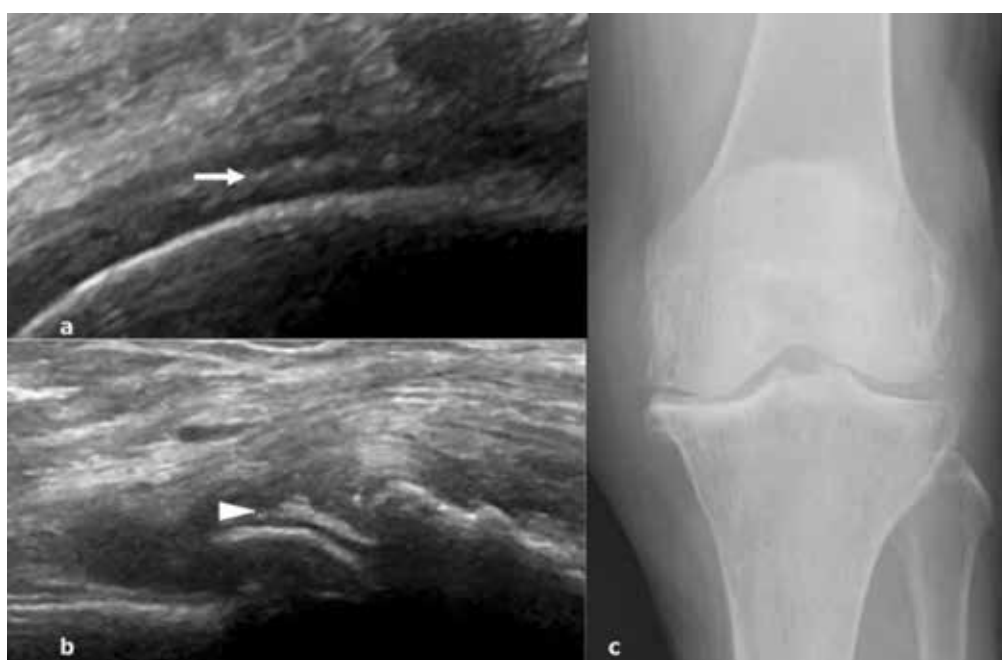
a Calcification in medial meniscus in patient with calcium pyrophosphate deposition disease (*arrow*). b Calcification in femoral hyaline cartilage (*arrow head*). c Conventional radiography in this patient. a, b Longitudinal scans.
